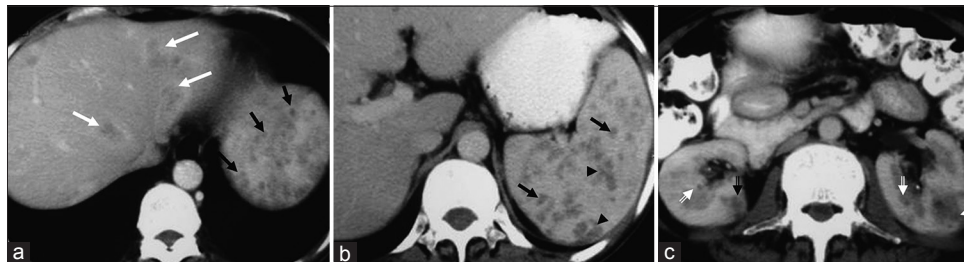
42-year-old man with hepatic, splenic, and renal tuberculosis. (a-c) Axial contrast-enhanced computed tomography images of the abdomen demonstrate coalescent hypodense lesions (macronodular) in the liver (white arrows in a), tiny hypodense lesions (micronodular or miliary) in the spleen (black arrows in a, b), and the kidneys (double-lined white arrows in c). Note the conglomeration of some of the splenic (black arrowheads in b) and renal lesions (double-lined black arrow in c) resulting in macronodular appearance.
